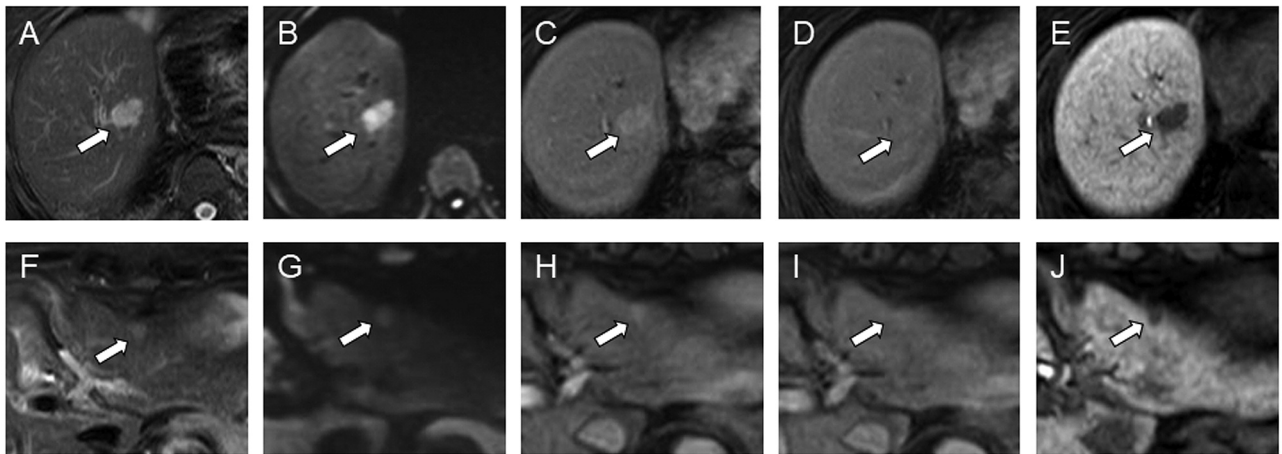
Gadolinium dethoxybenzyl-diethylenetriamine pentaacetic acid-enhanced enhanced magnetic resonance axial images of intrahepatic cholangiocarcinoma and bile duct adenoma. (A, F) Fat suppressed T2-weighted images; (B, G) Diffusion-weighted images; arterial phase (C, H), portal phase (D, I), and hepatobiliary phase (E, J) of the dynamic study images. Both tumors showed mild hyperintensity on T2-weighted images and high signal on diffusion-weighted images. The tumor showed early enhancement in arterial phases, mild delayed washout in portal phases, and low signal on hepato-biliary phases.
